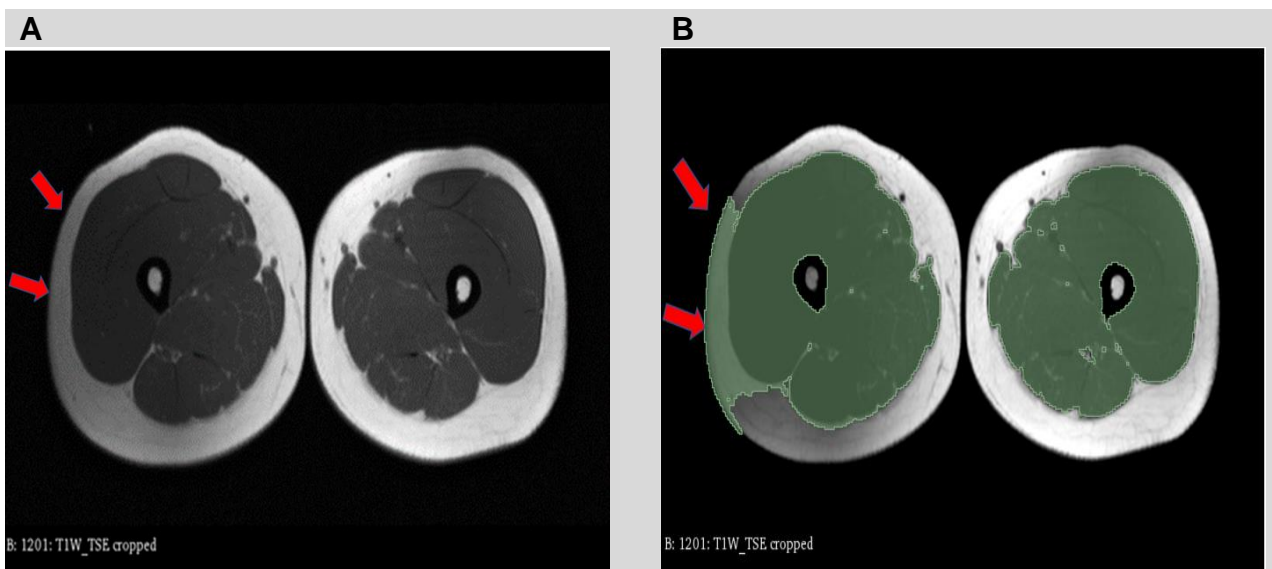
MRI T1TSE image showing (A) signal intensity degradation in the edge of the peripheral slice resulting in the dark area on the right thigh (left side of the image), and (B) the impact of this degradation on automated thresholding segmentation of the muscle.
